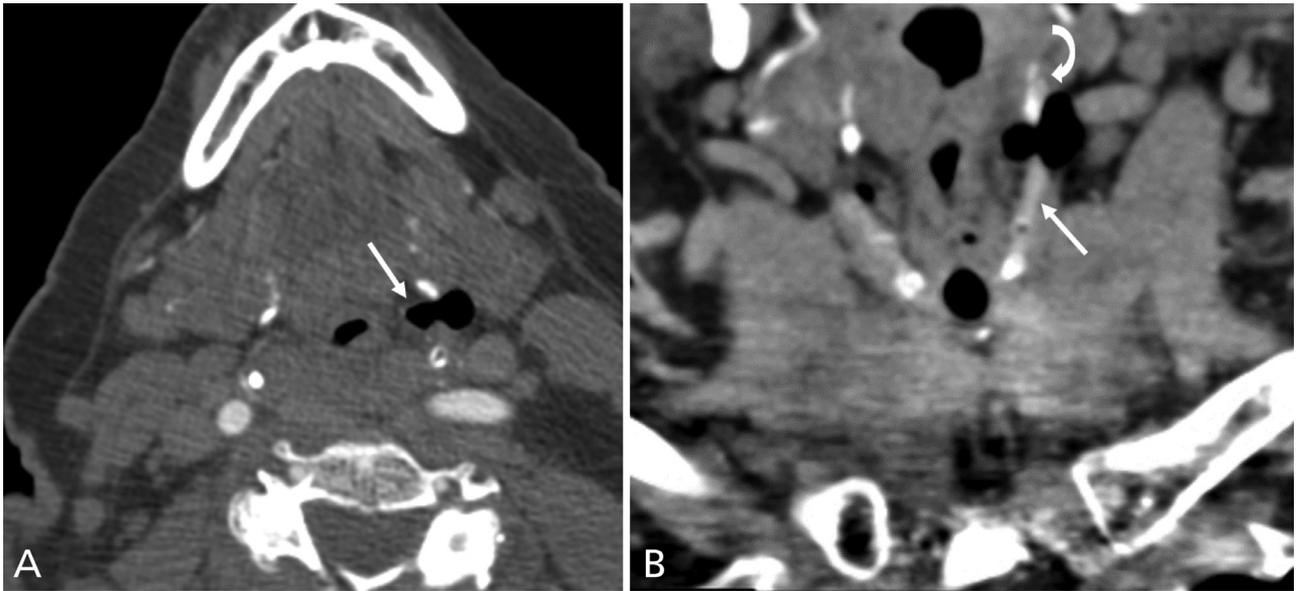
Left combined laryngocele. (A) Axial contrast-enhanced CT scan at the level of the thyrohyoid membrane demonstrates an air containing structure in the left paraglottic space (arrow) herniating through the thyrohyoid membrane. (B) Coronal imaging of the combined laryngocele clearly demonstrates its herniation between the thyroid cartilage (arrow) and the hyoid bone (curved arrow).
